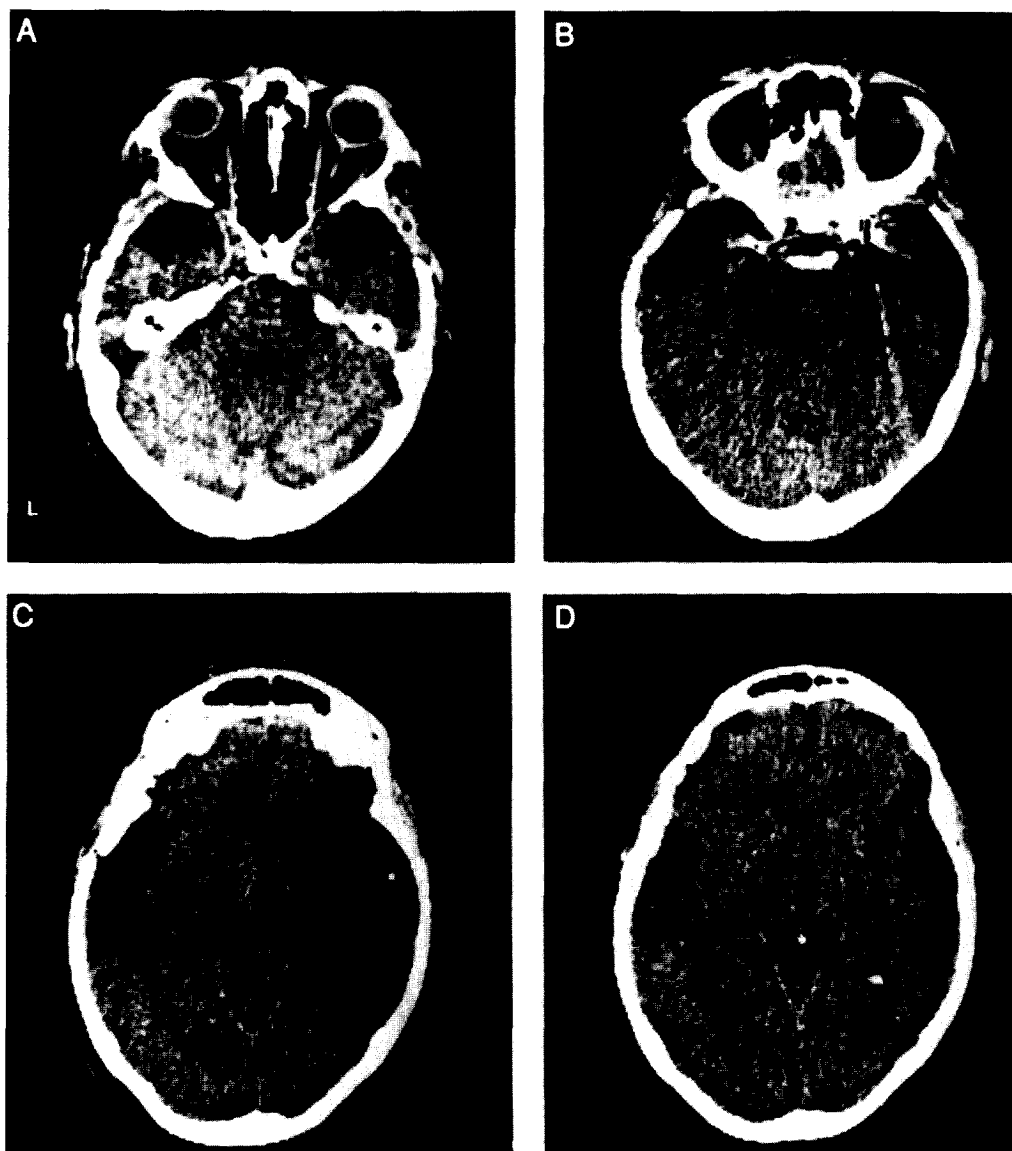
Case C.N. Contiguous, 8 mm thick, horizontal CT sections obtained without intravenous contrast in March 1988, ~1 year after C.N.'s second craniotomy. Hypodensities are seen in the superior temporal gyri (B–D), middle temporal gyri (B–D) and temporal poles (A–B) of both hemispheres, and in the insula (C–D) and inferior frontal gyrus (C–D) of the right hemisphere. Additional hypodensities in both temporal poles appear in the section inferior to A (not shown). Aneurysm clip artefacts are seen in B.
